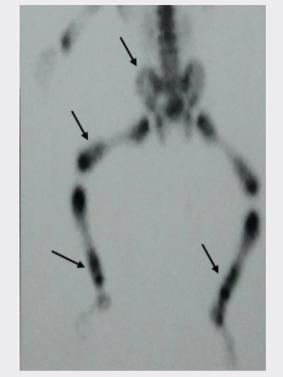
Skeletal scintigraphyhyperfixation in lower third of the tibias and femurs and moderate and heterogeneous hyperfixation in the right iliac wing
